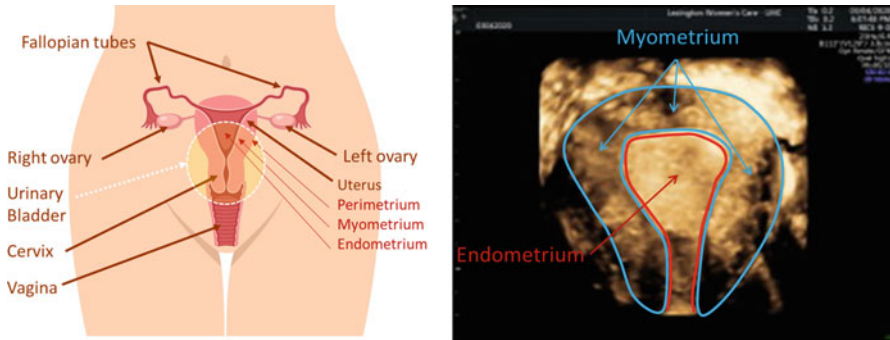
The female reproductive system. The female reproductive tract includes the female gonads or ovaries, the fallopian tubes, the uterus, the cervix, and the vagina. The uterus consists of several layers, including the inner endometrium and the outer muscle layer or myometrium. The endometrium and myometrium can be distinguished using either two-dimensional or three-dimensional coronal ultrasound imaging. 3D imaging helps provide an optimal image of the uterus contour
